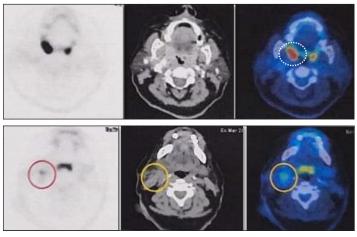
PET-CT scan showing enhancing right palatine tonsil (dashed circle) and right level II lymph nodes (solid circles)
